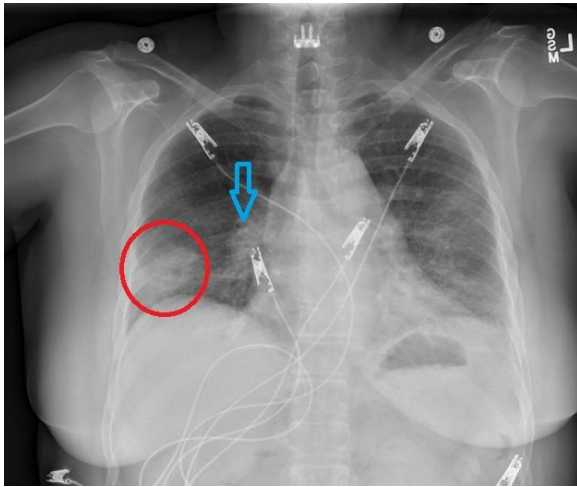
A chest radiograph demonstrates a wedge-shaped opacity in the right lung base (red circle) and enlargement of the right descending pulmonary artery branch (blue arrow) consistent with a Hampton hump and Palla sign, respectively.
